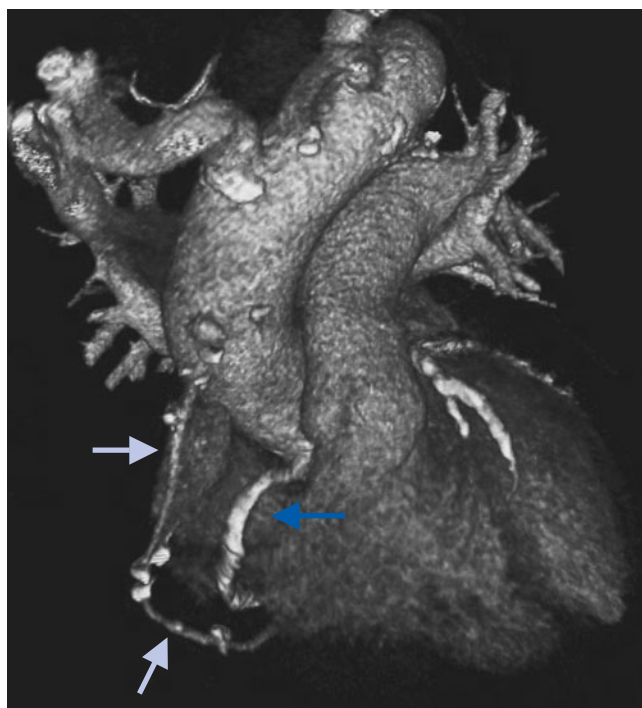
Cardiac CT performed to evaluate possible radial graft occlusion. The patient had surgery 1 month prior and presented with recurrent angina. The radial-to-RCA graft could not be selectively catheterized at conventional angiography and also was not seen at aortic root injection. Three-dimensional volume-rendered image demonstrates patent radial graft (*gray arrows*) to RCA (*blue arrow*). The anastomosis is not seen on this orientation.
